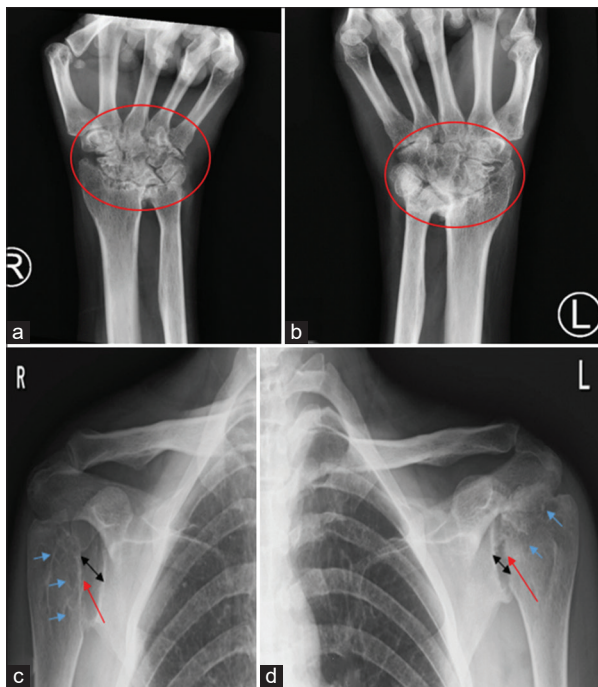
(a and b) Radiographs of bilateral wrist joints showing multiple erosions affecting radio-ulnar and carpal bones with joint space narrowing, sclerosis and ankyloses (red circles); (c and d) Radiographs of bilateral shoulder joints showing complete resorption of right humeral head (red arrow), multiple cysts (blue arrows) and widening of glenoid cavity (black double arrow head). The left shoulder shows resorption of the left humeral head (red arrow), cystic changes (blue arrows), and pseudo-widening of the glenoid cavity due to humeral head and acetabular erosions (black arrow heads). Deformity of the bilateral shoulder joints is noted as well
